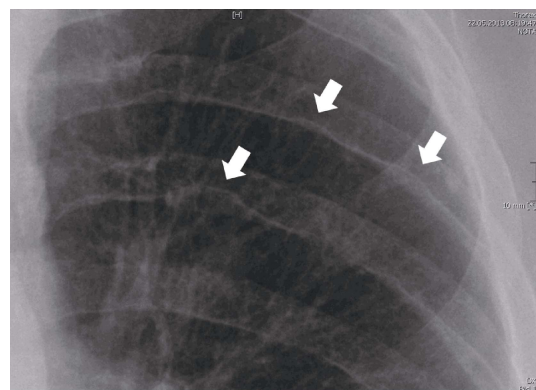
Chest radiography: Rib notching (white arrows).
